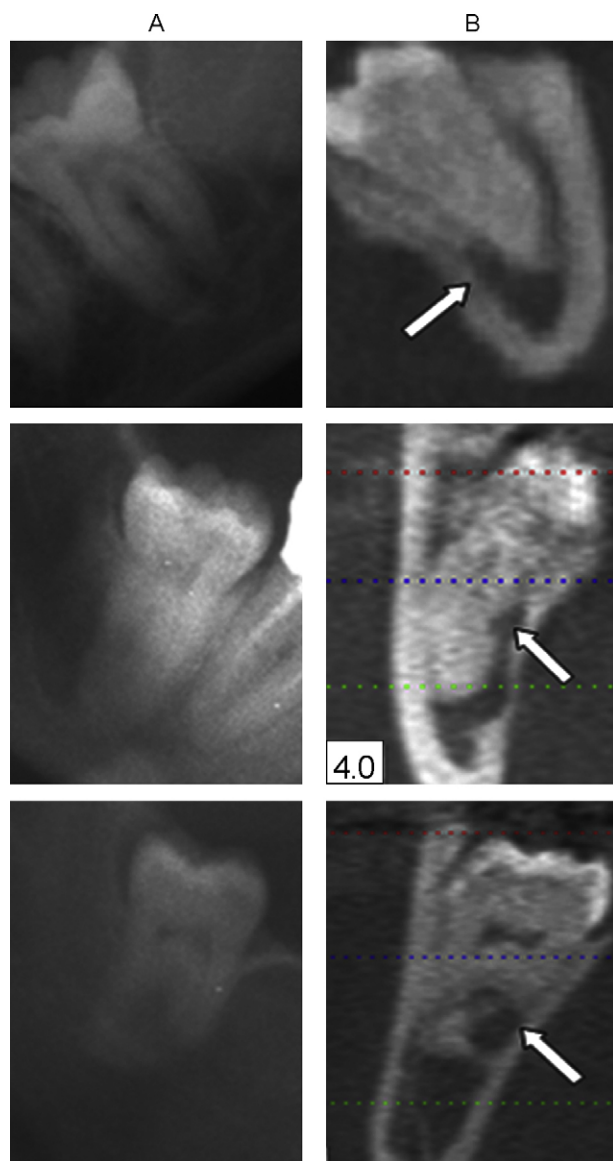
Three cases are shown with darkening of the tooth root on panoramic radiographs (A). The corresponding coronal CBCT images show grooving of the tooth root (arrows) at the lingual side (B). In all these cases the IAN was exposed during surgery and postoperative sensory impairments occurred in all these patients. One patient continued to have some sensory impairment after 6 months.
